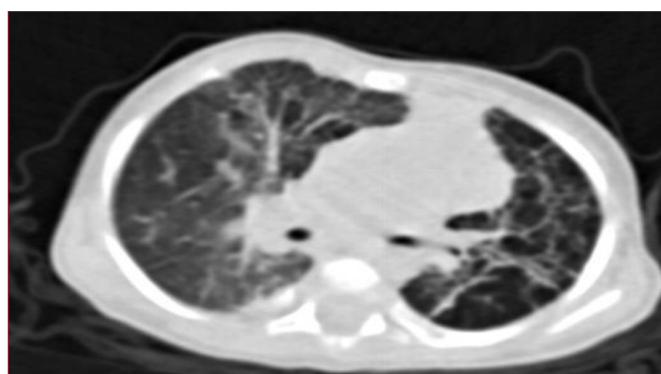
Swyer-James (Macleod Syndrome), CT demonstrate long-standing hyperlucency of the right lower lobe
